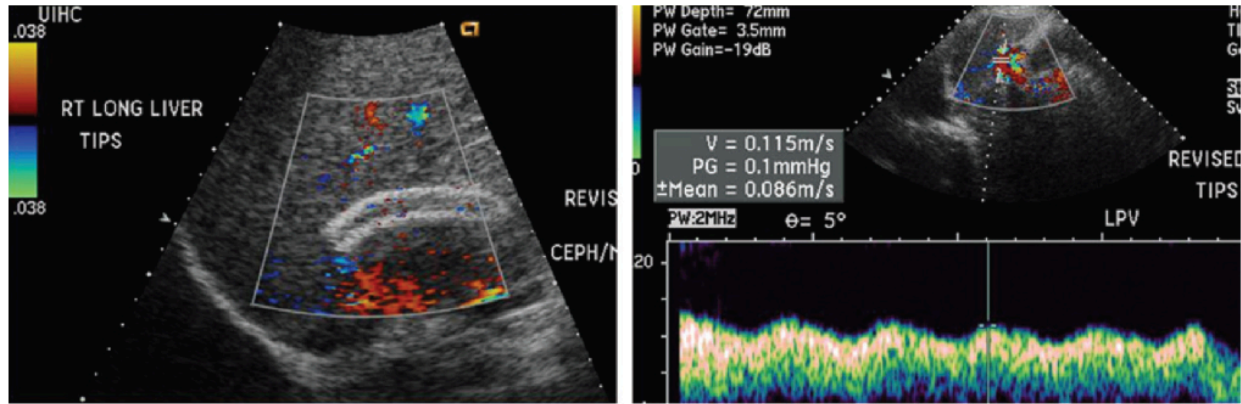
TIPS malfunction (occlusion). (a) Color Doppler US image obtained in the longitudinal plane shows a TIPS with no color flow, a finding that represents direct evidence of TIPS malfunction. (b) Spectral Doppler US image shows hepatopetal flow in the left portal vein. Flow in the right portal vein was also hepatopetal. The prior examination, performed when the TIPS was patent, showed flow in these veins to be hepatofugal; thus, the now hepatopetal flow is indirect evidence of malfunction.
